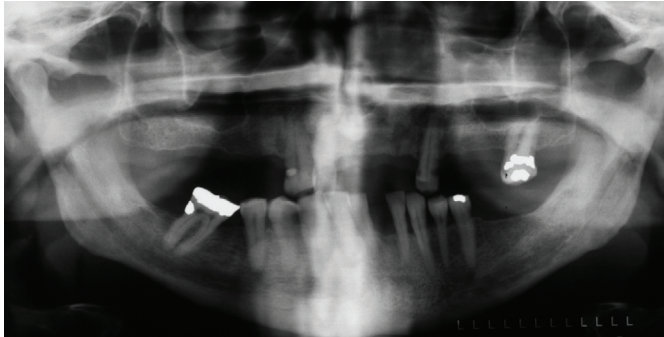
Orthopantomograph showing remaining teeth at the time the patient sought treatment, showing universal bone loss.
